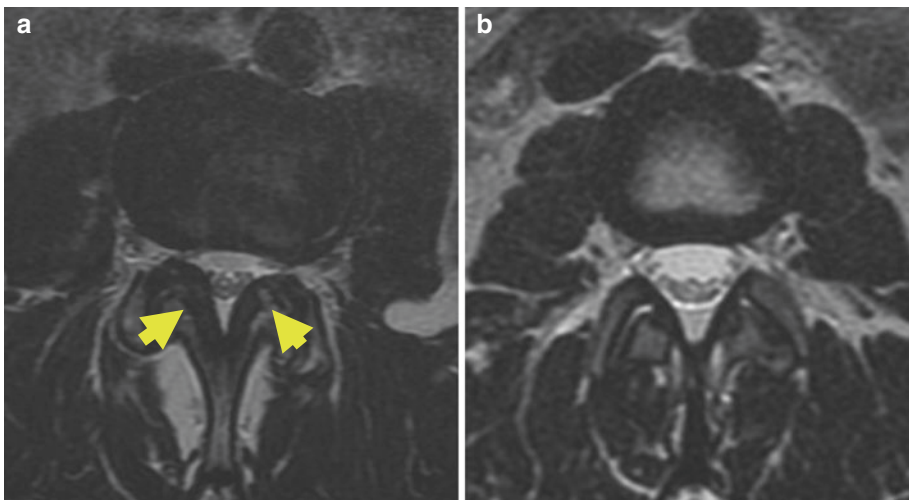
Axial T2-weighted images of the lumbar spine demonstrating ligamentum flavum infolding (arrows in a), compared to a normal ligamentum flavum (b)
